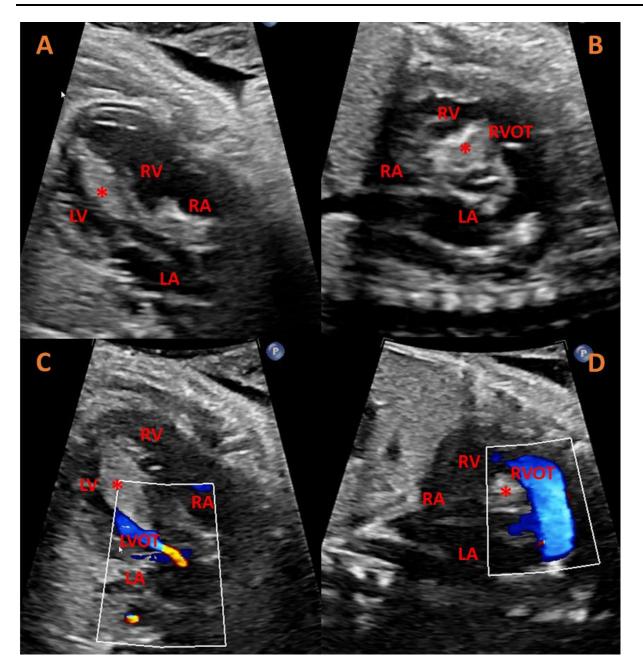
Fetal echocardiogram of cardiac rhabdomyomas at 34 and 6/7 weeks' gestation while on maternal oral sirolimus therapy. A. 4 chamber view demonstrating decreased size of the LV mass. B. Short axis view demonstrating decreased size of the RV mass. C. Apical 5 chamber
